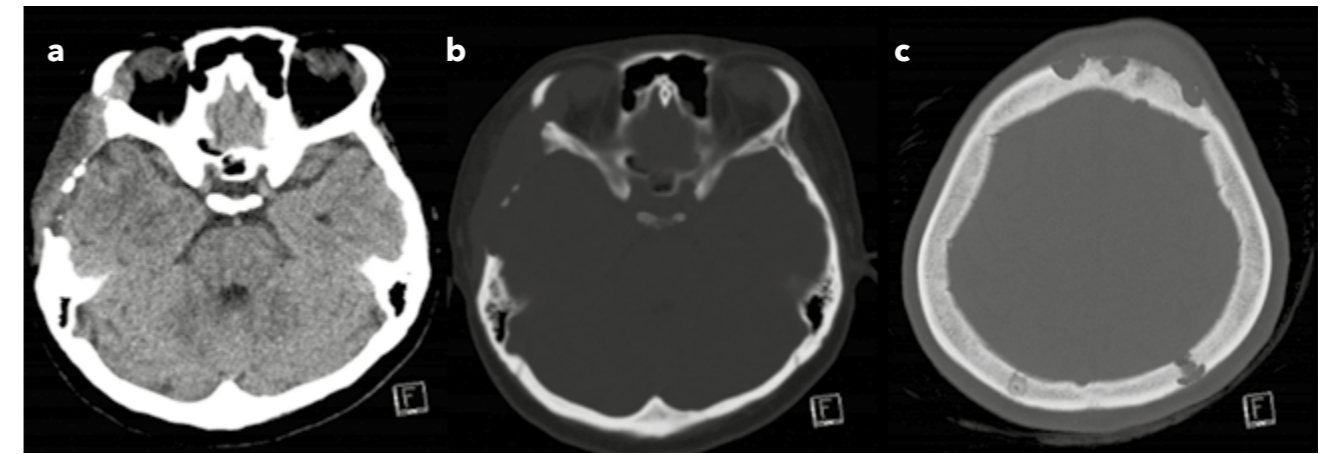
Axial non-contrast CT brain in (a) Soft tissue window and (b,c) Bone window.
